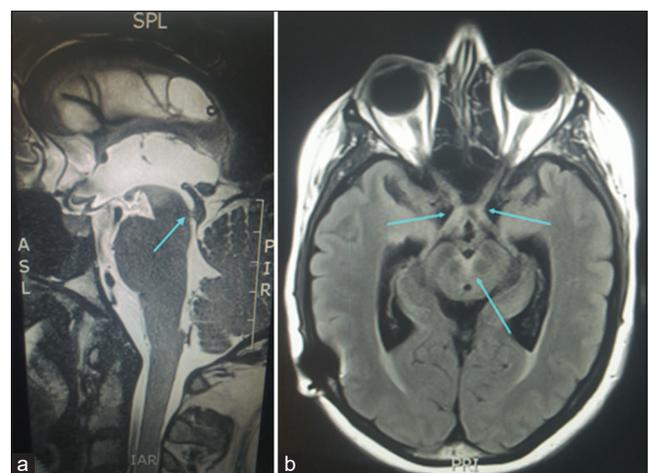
Previous MRI (a) High-resolution T2 MRI showing cerebral aqueduct stenosis/web. (b) Axial FLAIR MRI showing abnormal signal in the optic chiasm extending to bilateral optic tracts and in the midbrain from the interpeduncular fossa extending between the red nuclei to the area of the oculomotor nuclei.
